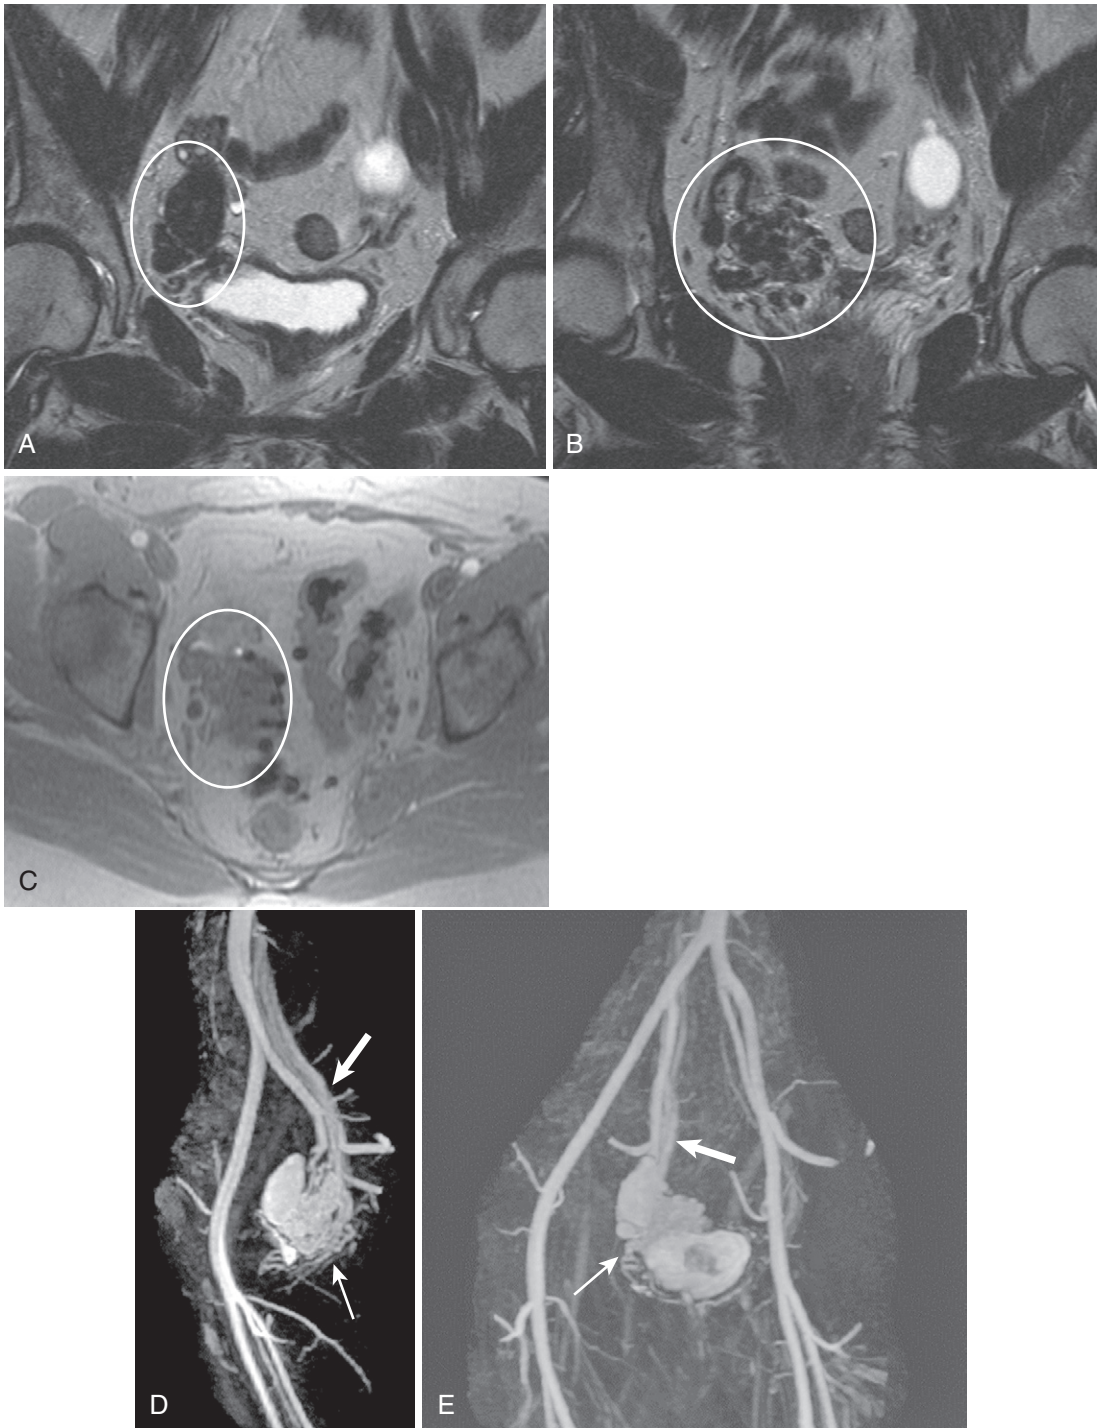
Pelvic arteriovenous malformation (AVM). A hypointense pelvic AVM with ovoid and serpiginous morphology (*circle* in A and B) coexisting on adjacent slices of a coronal T2-weighted sequence (A and B) lacks signal voids on the companion T1-weighted in-phase gradient echo image (*circle* in C). (Adjacent blooming hypointensities arise from gas in sigmoid diverticula.) D and E, The reformatted maximal intensity projection images (D) from the arterial phase of the pelvic magnetic resonance angiography (MRA) demonstrates pronounced enhancement (*thin arrow*) with early draining into the internal iliac vein (*thick arrow*)—compare with the contralateral side (E).
